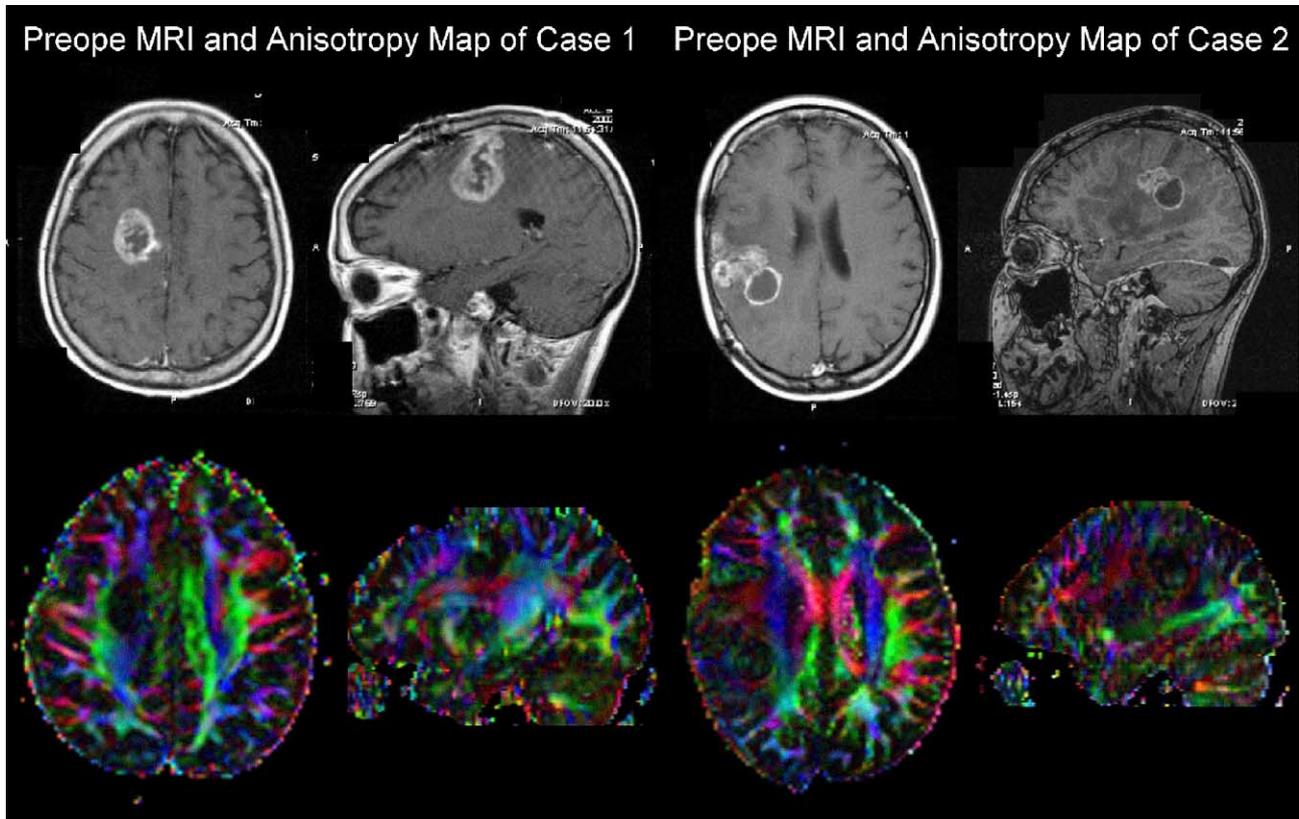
Preoperative sagittal and axial Gd-enhanced MR images (upper rows) and relative anisotropy maps (lower rows) of both case 1 (left two rows) and case 2 (right two rows). Each color of the anisotropy map indicates the principal eigenvector (green: anterior–posterior; red: right–left; and blue: inferior–superior). The intensity of the color correlates with the relative anisotropy.
